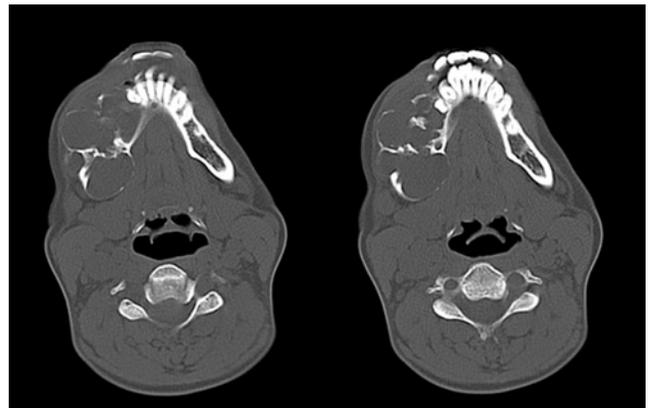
Axial Images of CT mandible showing expansile multilocular hypoattenuating lesion on the right side with sclerotic changes and displacement of teeth and adjacent structures.
